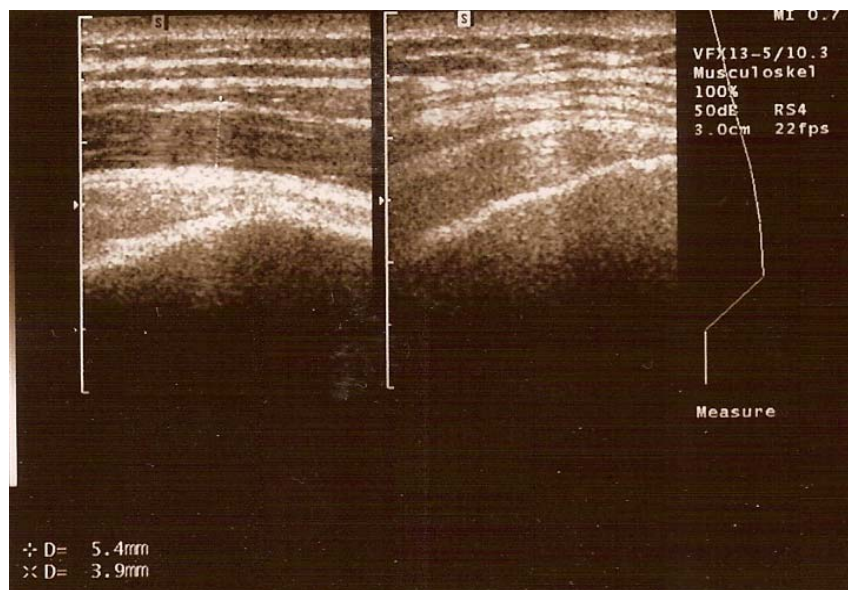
Ultrasound muscle images allow to measure at the neurovascular pole the thickness of the Tibialis Anterior 3.9 mm (right, denervated) and 5.4 mm (left, innervated).
